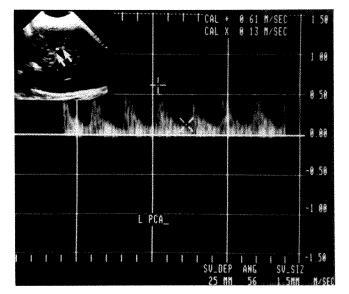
Pulsed Doppler study of ipsilateral posterior cerebral artery. Posterior cerebral artery and Doppler cursor (*arrows*). Doppler angle is 56°; absolute systolic (+) and diastolic (X) velocities are given in upper right-hand corner.
